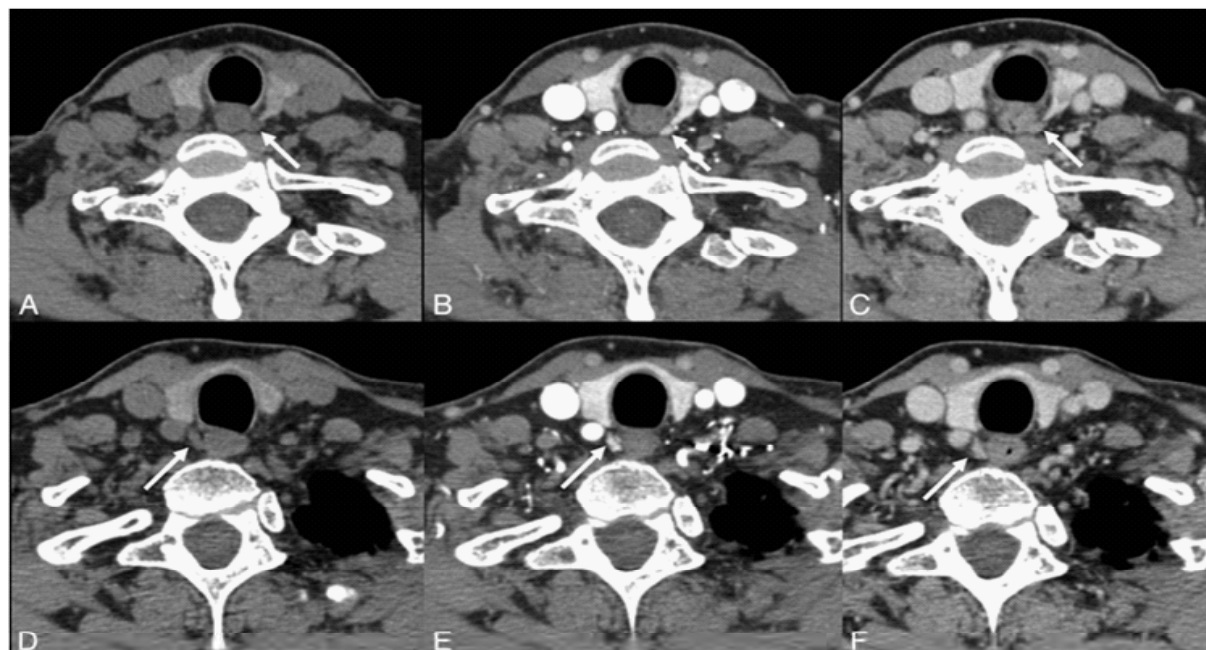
Axial CT showing avidly enhancing lesions in the orthotopic superior location (arrows) bilaterally with rapid washout of contrast greater than that of the adjacent thyroid gland (A and D: noncontrast phase; B and E: initial postcontrast "arterial" phase; C and F: delayed post-contrast phase).
